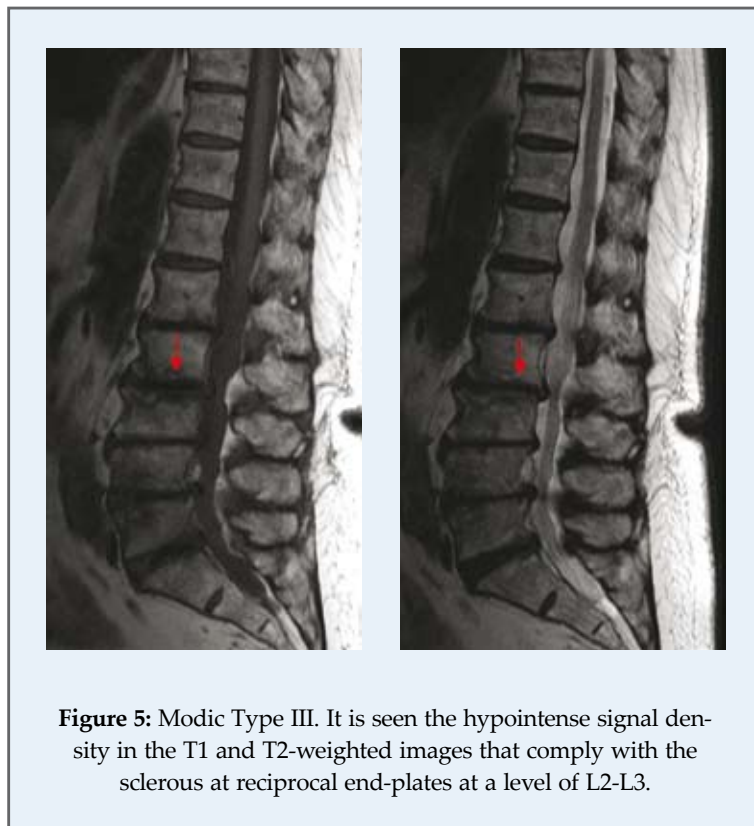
Modic Type III. It is seen the hypointense signal density in the T1 and T2-weighted images that comply with the sclerous at reciprocal end-plates at a level of L2-L3.
